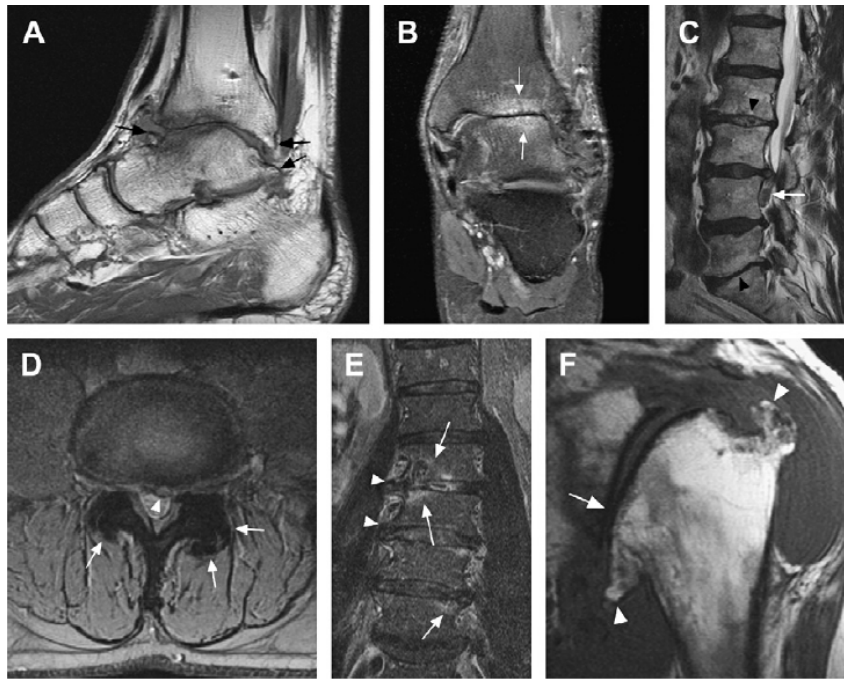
Examples of 1.5-T MR imaging of advanced OA. (A) Sagittal T1-weighted MR image of post traumatic ankle OA shows large periarticular osteophytes (arrows). (B) Coronal T2-weighted fat-suppressed MR image shows periarticular subchondral BMLs (white arrows). (C) Sagittal T2- weighted MR image of lumbar spine OA shows disc space narrowing at L2 to L3 and at L5 to S1 (arrowheads). There is an additional inferiorly displaced disc herniation at L3 to L4 (white arrow). (D) Axial T2-weighted gradient-echo MR image at the level of L3 to L4 shows hypertrophic facet joint OA (white arrows) and a small medial disc herniation (arrowhead). (E) Coronal short tau inversion recovery (STIR) MR image of the lumbar spine demonstrates peridiscal edema-like lesions at L2 to L3 and at L4 to L5 (arrows). Note the peridiscal lateral osteophytes (arrowheads). (F) Sagittal T1-weighted MR image of advanced shoulder OA shows large humeral osteophytes (arrowheads) and severe JSN and cartilage loss (arrow).
